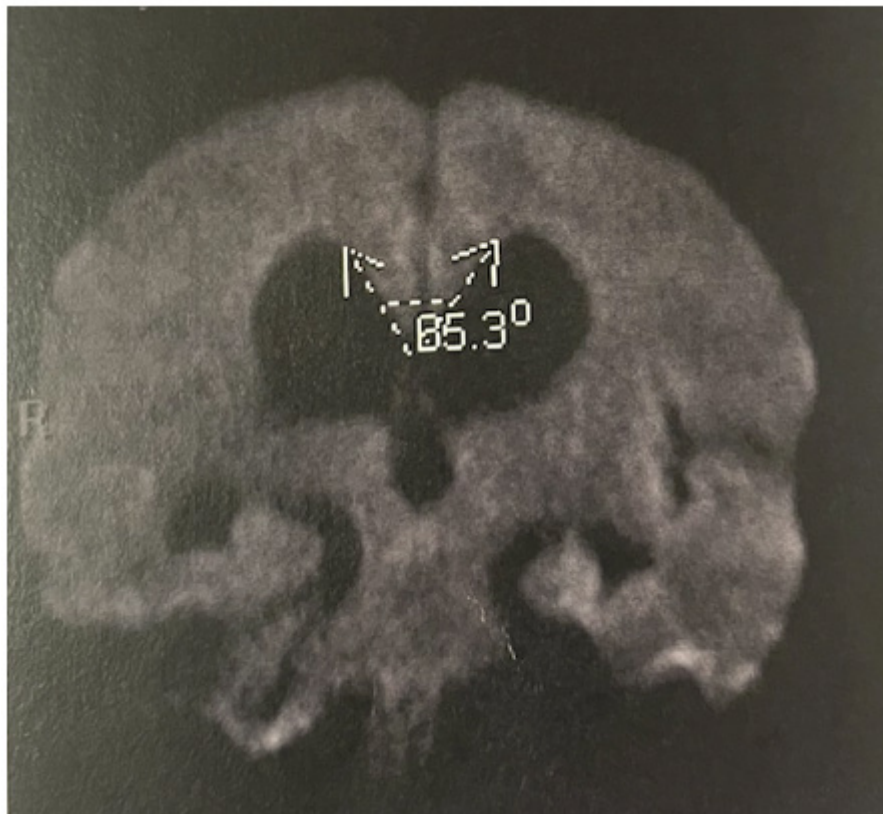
Head MRI Transverse Axis T2 FLAIR Sequence.
